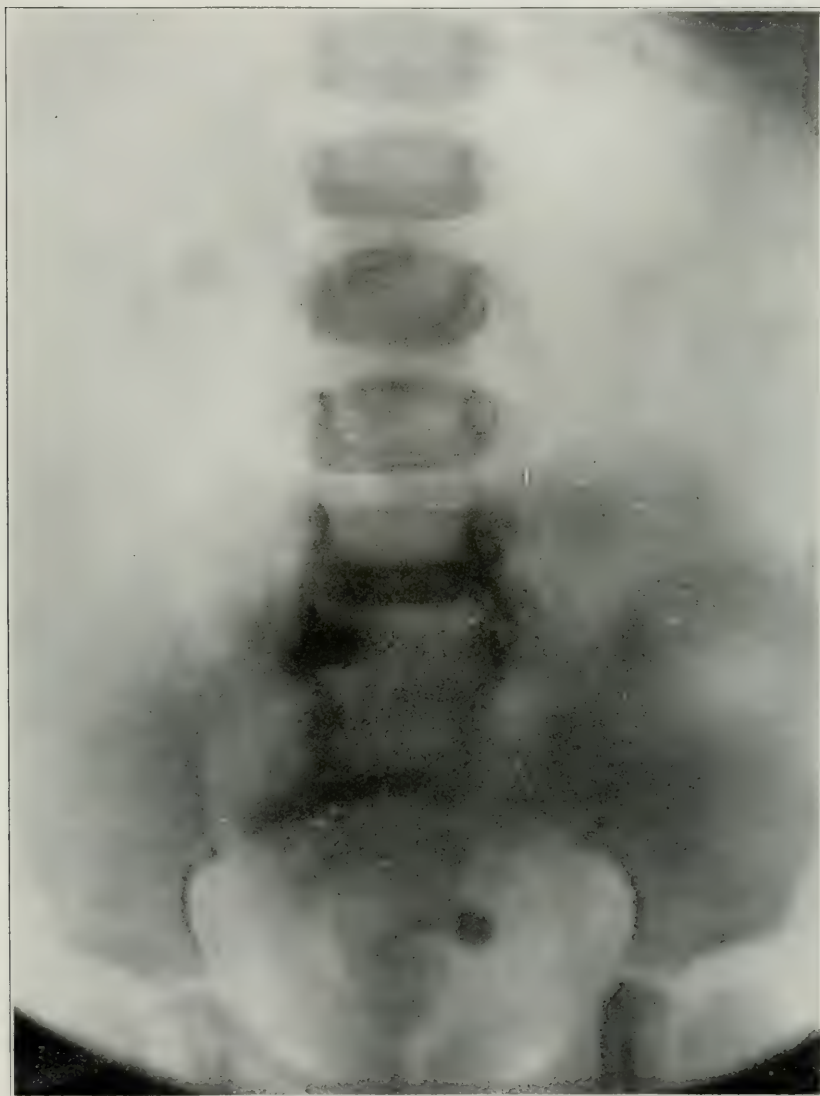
Radiograph showing two calculi in right kidney, one in the bladder and a third shadow at the crest of the right ilium—probably stone in the ureter.
